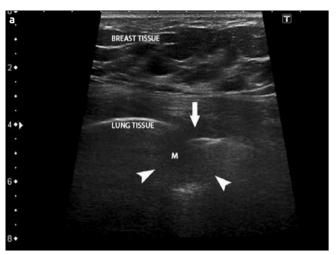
a, b. a) Ultrasonographic examination detected metastatic mass lesions compatible with nodular metastasis, which were peripherally localized, adjacent to the visceral pleura under the breast tissue (arrowheads). The fact that the lump was mobile during respiration was seen to indicate that it was not a parietal pleura invasion (arrow). b) The lung CT to check for metastasis detected a nodular mass lesion adjacent to the pleura under the breast tissue on the left lung (arrowheads, arrow).
